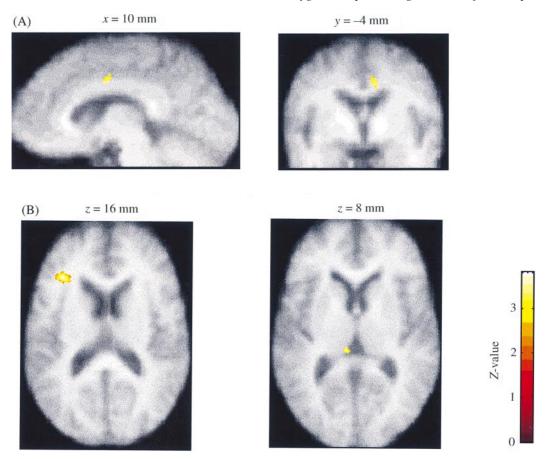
Statistical parametric maps showing brain regions responsive to increases in the intensity of fearful expression. (A) Sagittal and coronal sections showing an area of activation in the right cingulate with a maximal focus x = 10, y = -4, z = 32. (B) Transverse sections showing areas of activation in the left anterior insula (in the z = 16 mm slice) and left pulvinar (in the z = 8 mm slice). In both A and B an uncorrected *P*-value of 0.01 was used as the threshold for the contrasts. The areas of activation are all displayed on the mean MRI images produced from the co-registered structural MRIs from all five subjects. The maximal foci of activation and the associated *Z*-values are given in Table 2A.
